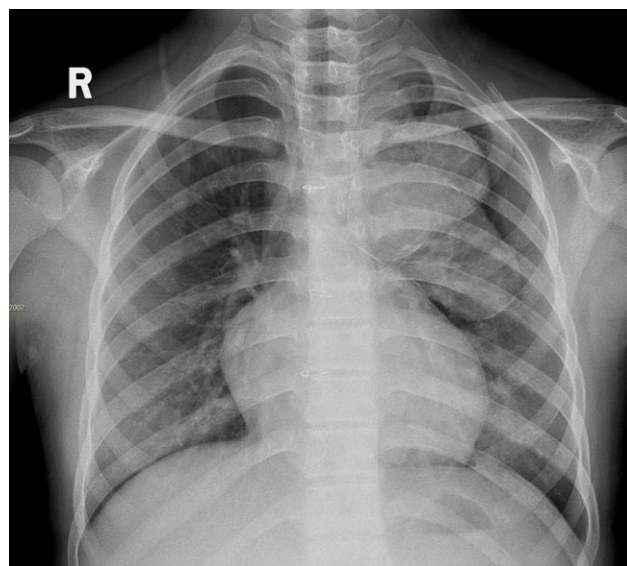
Chest X-ray in anterior–posterior view demonstrates the contours of two large pseudoaneurysms in the left lung.
